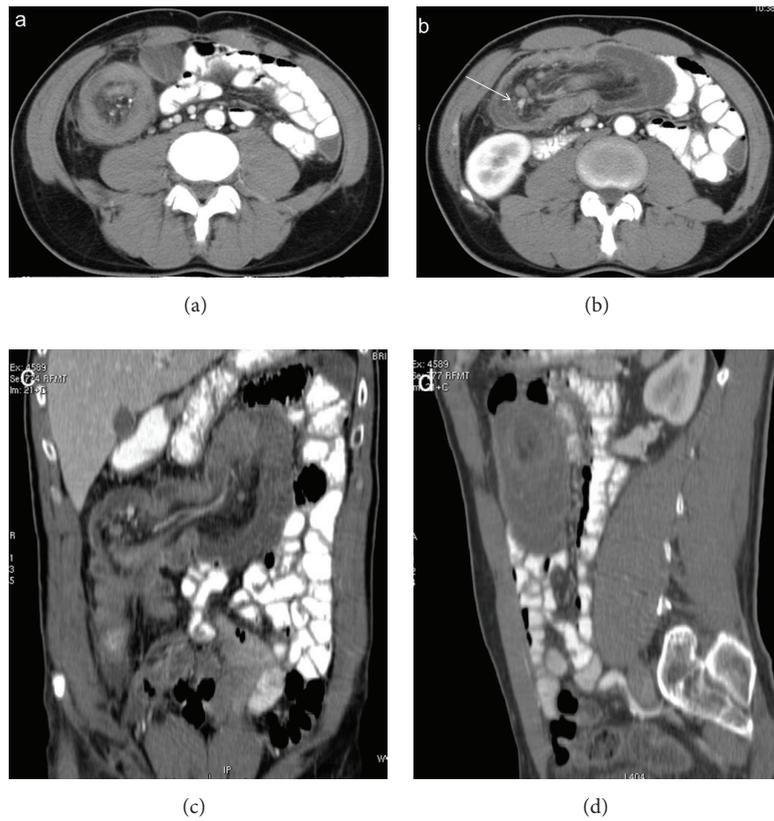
Enterocolonic (ileocaecocolonic) intussusception. Intussusception may present as a target (a), reniform bilobed (b, c), and a sausage-shaped (d) mass depending on the different axial CT scans or reformatted planes. Mesenteric vessels appear as enhanced linear structures between hypodense mesenteric fats (arrow). Dilated proximal bowel loops are opacified with oral contrast.
